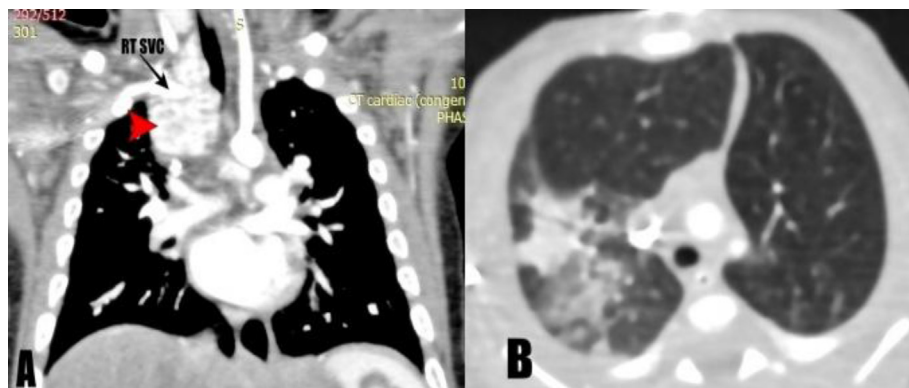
Example of Chest findings: (a) Coronal reformatted multi-slice computed tomography image shows a well-defined enhancing mass (red arrowhead) at the right side of the lower neck extending to right side of the middle mediastinum compressing the right lateral tracheal wall and totally encasing the right subclavian artery (RT SCA). Pathologically proven mediastinal hemangioma. (b) One month old patient presented with tricuspid atresia, axial multi-slice computed tomography shows few patches of consolidation at the right upper lung lobe associated with area of ground glass densities. MSCT: multi-slice computed tomography, RT SCA: right subclavian artery.
